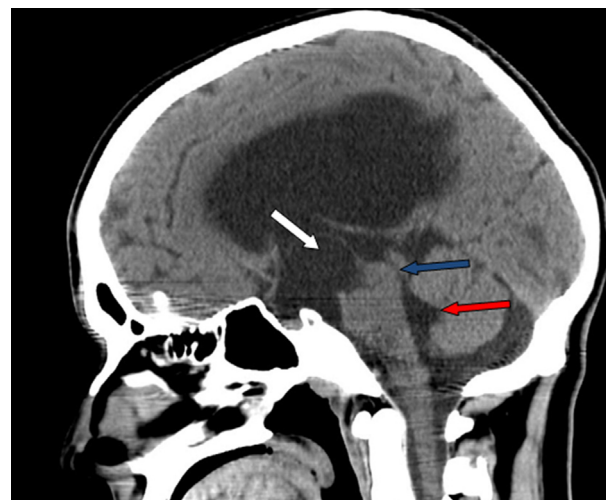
Sagittal CT scan of the brain showing an irregular sellar and suprasellar cystic lesion (white arrow), dilated lateral ventricles and normal fourth ventricle (red arrow) and a patent aqueduct of Sylvius (blue arrow).
